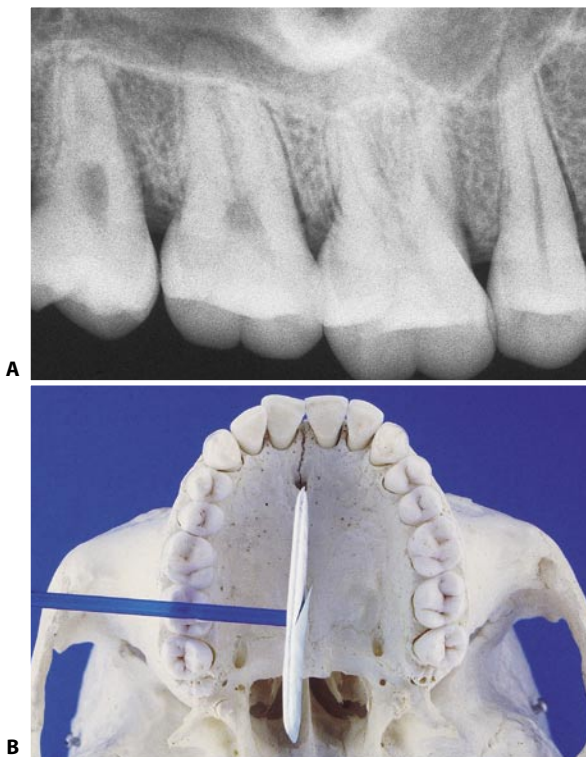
A. This radiograph demonstrates the apices of the buccal roots of the second molar superimposed on the palatal root. B. Path of the X-rays in a standard projection.
